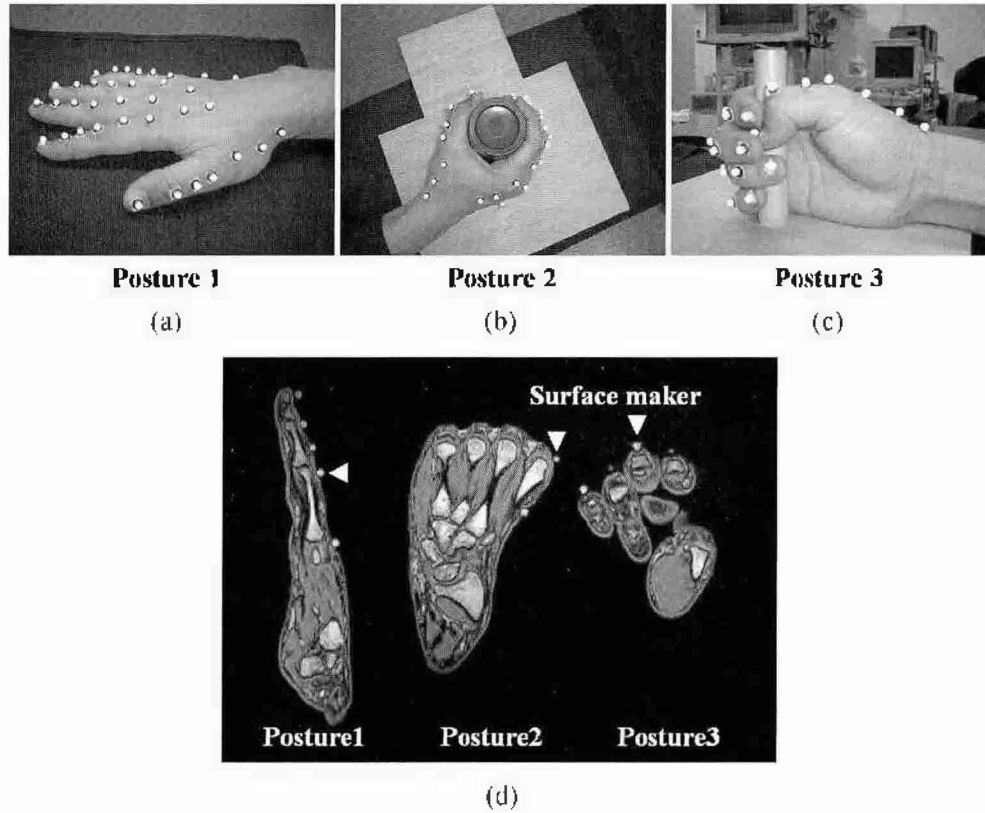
MR scanning of the hand with surface markers in 3 postures: (a) Posture 1, (b) Posture 2, (c) Posture (3), (d) Typical MR images of the three postures.
